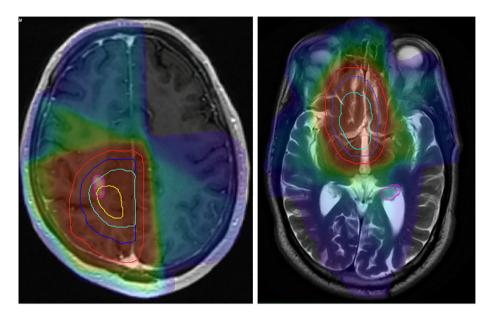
Two examples of recurrences. The dose distribution and the structure set are superimposed on the MRI at the time of recurrence. The GTV is in yellow, the original CTV is dark blue, the PTV is red. The CTV5mm is in light blue. The rTV is in pink. To the left is a T1 recurrence classified as "central" with regards to the original CTV, "inside" with regards to the CTV5mm, and "in field" with regards to the 95% isodose. To the right is a parahippocampal (and infratentorial) T2 recurrence classified as out-field.
